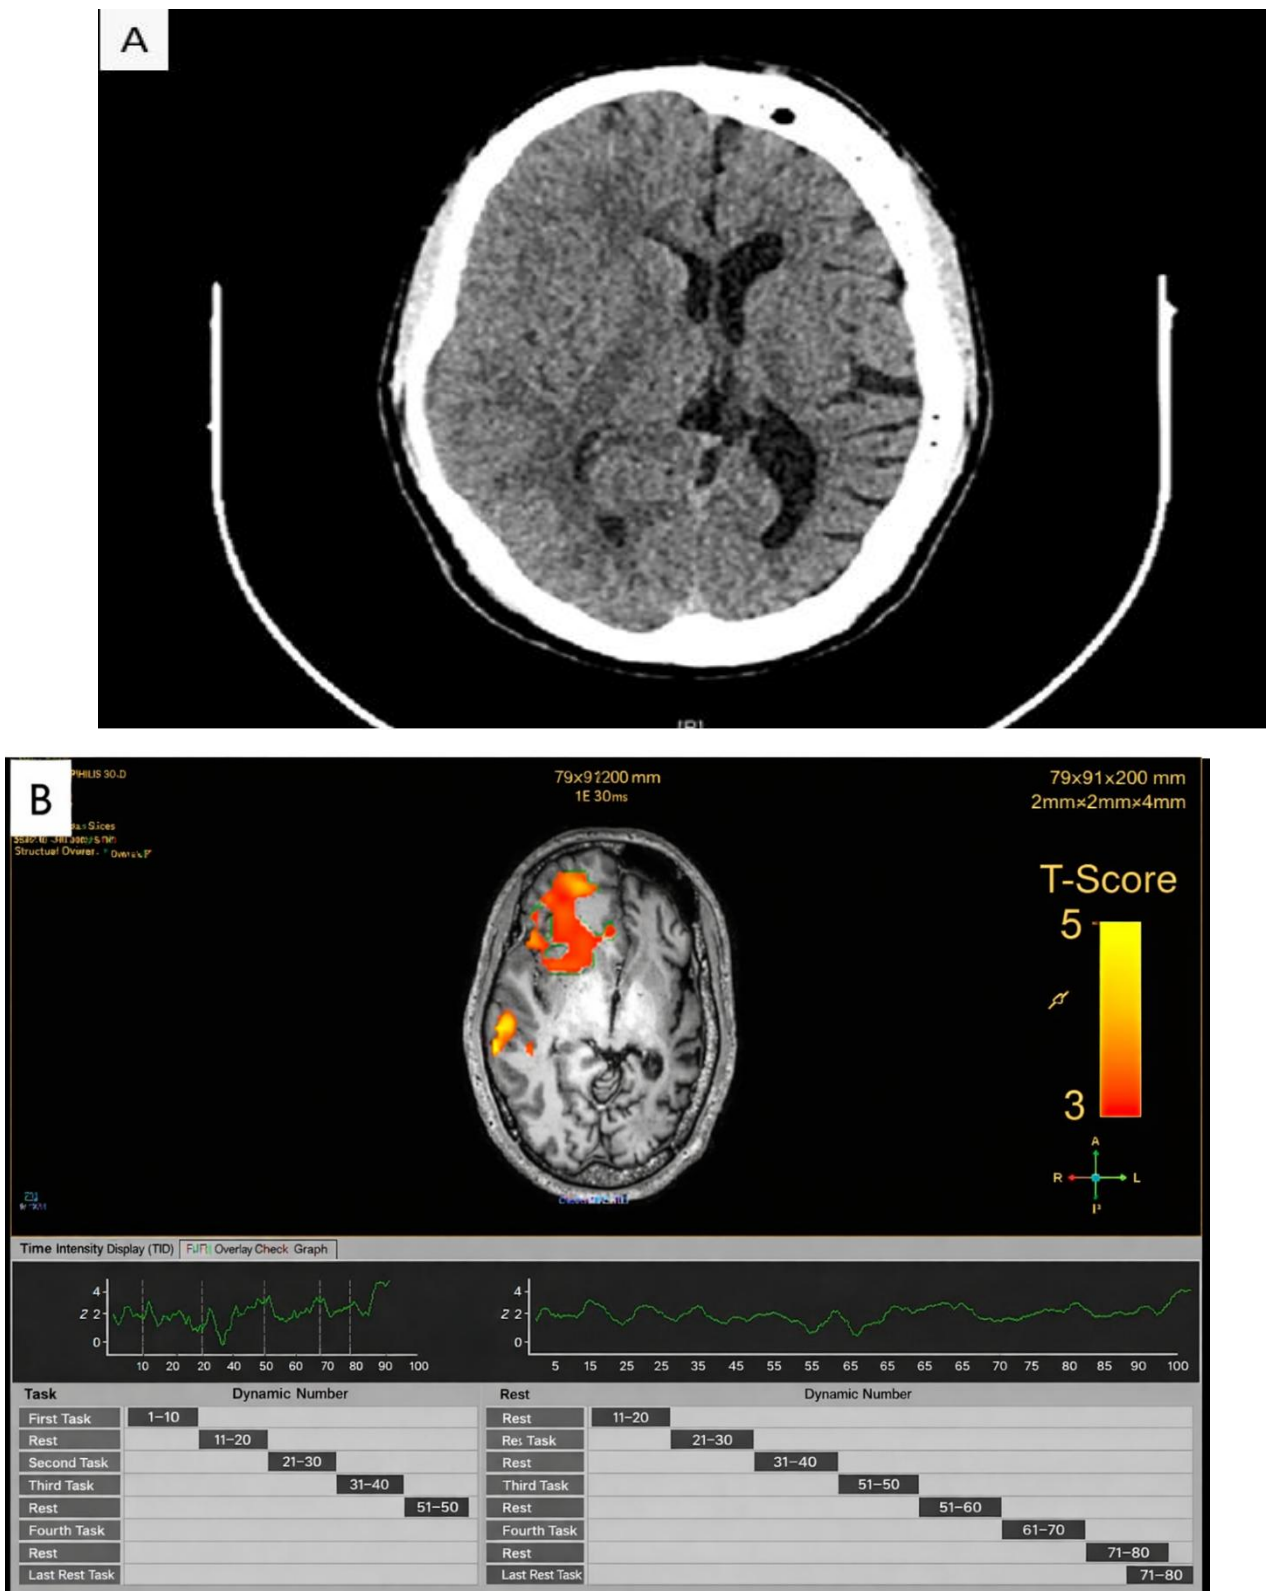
(A) Axial section of a CT scan showing atrophy of the left cerebral hemisphere. (B) Functional MRI showing intact signals in the right cerebral hemisphere, with absent activity in the left and hyperpneumatization of the left frontal sinus
